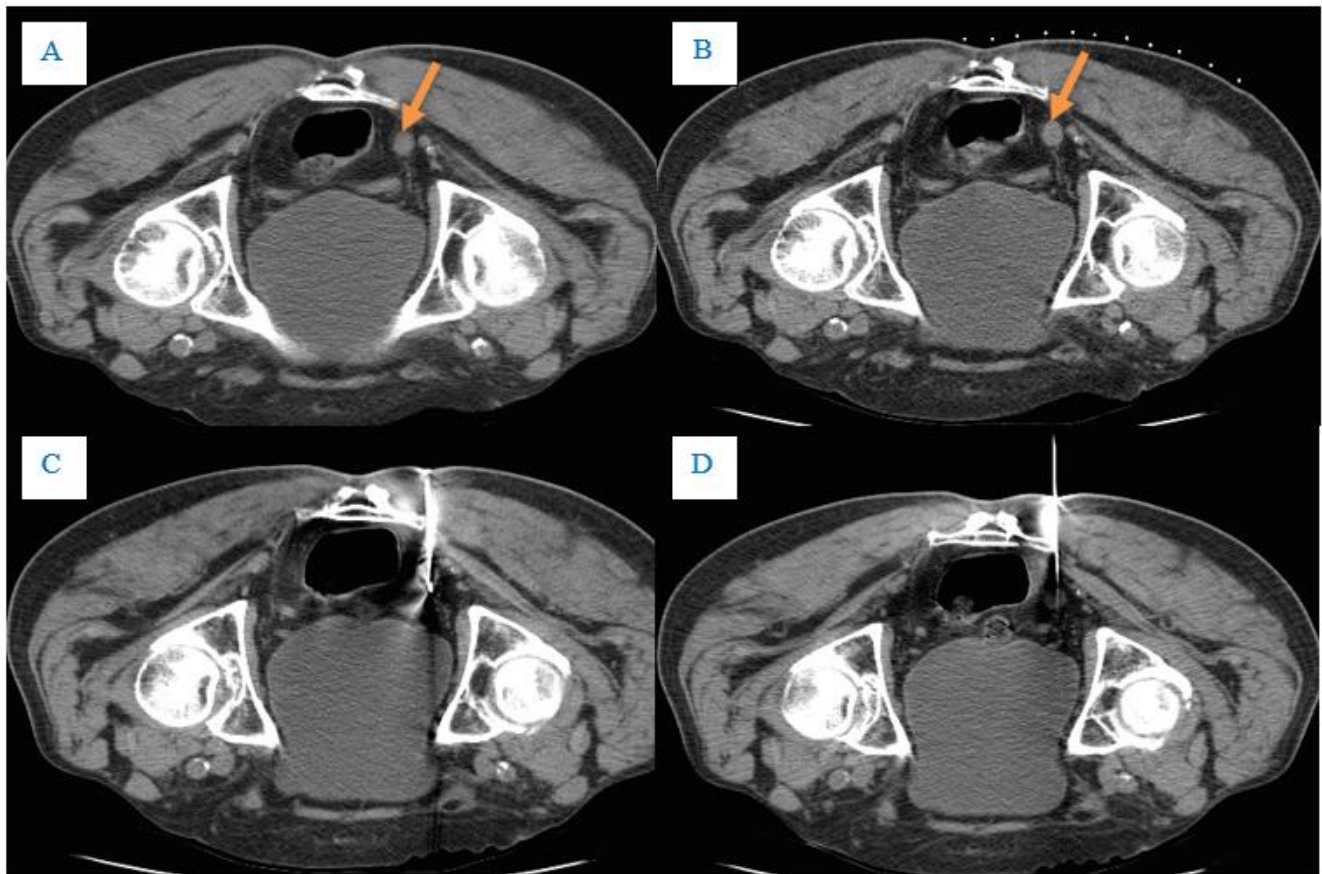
Axial and coronal contrast-enhanced CT images show a 12-mm right pararectal soft-tissue nodule adjacent to the rectal wall (arrow) (A, B). CT-guided biopsy was performed using a 17G coaxial introducer needle with three passes of an 18G core biopsy needle (C, D)
